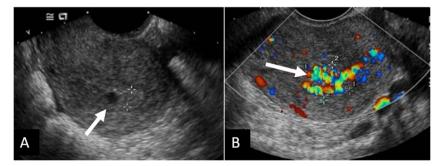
Twenty-three-year-old female postdilatation and curettage presents with bleeding per vaginum. a, b Transvaginal ultrasound performed for retained products of conception demonstrates hypoechoic
